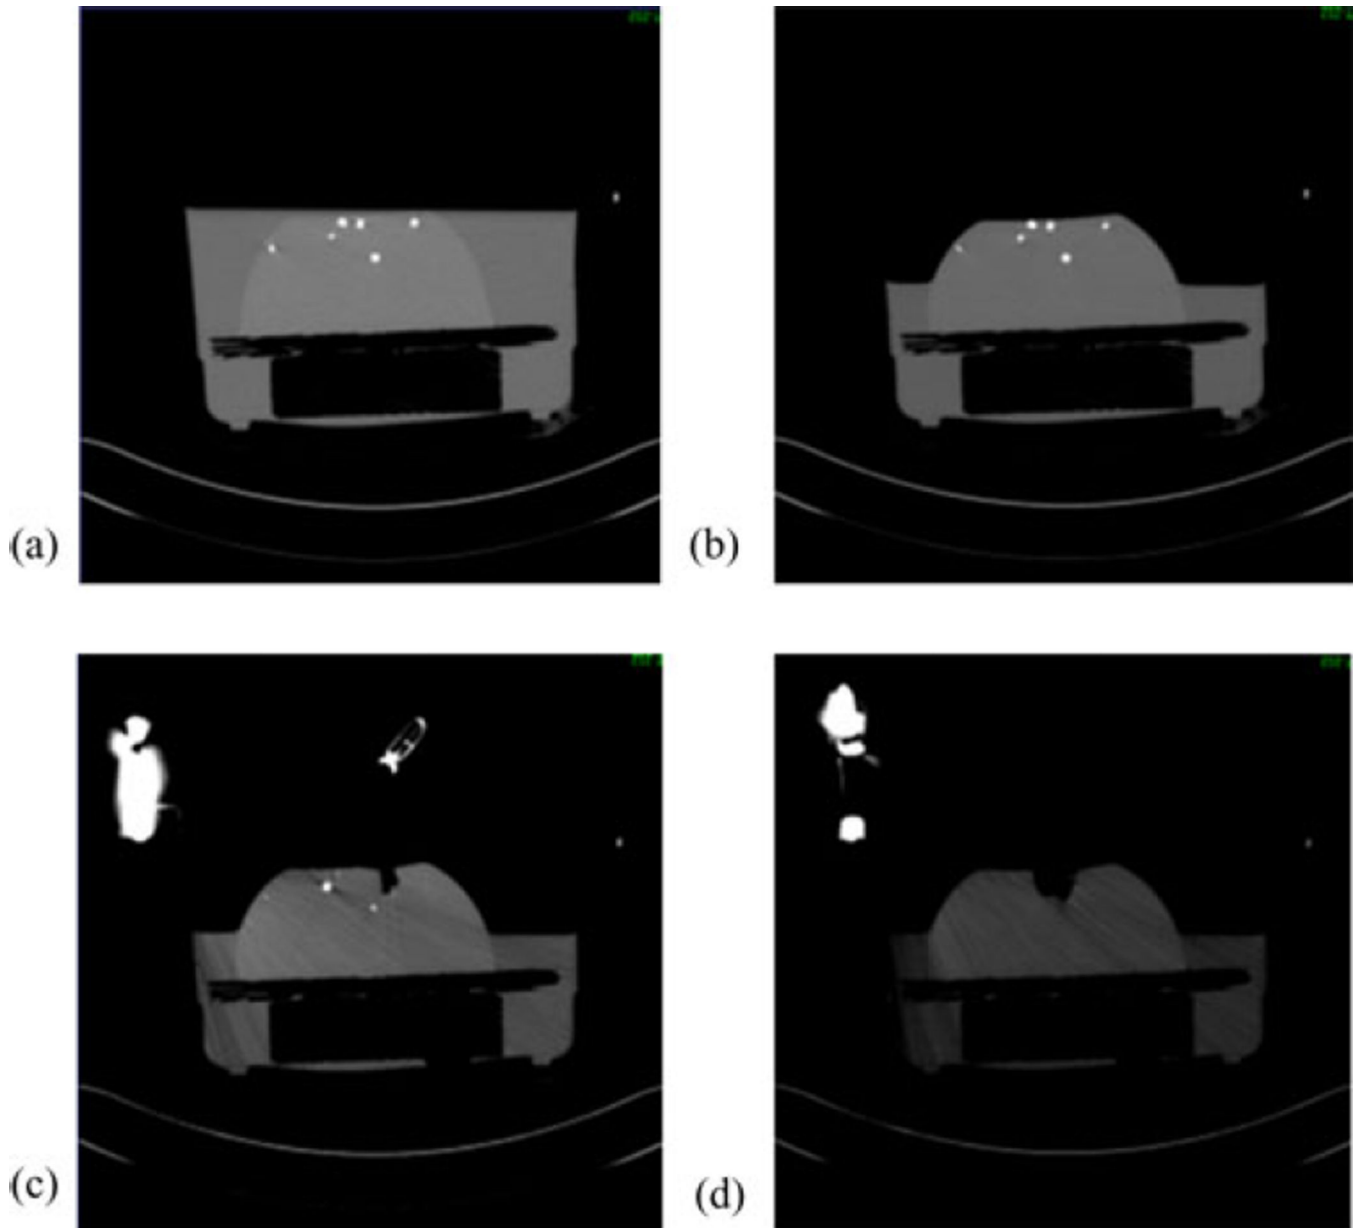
CT images acquired at different time points. (a) Undeformed image, (b) after water drainage, (c) after retractor is placed, and (d) after retractor is deployed.
